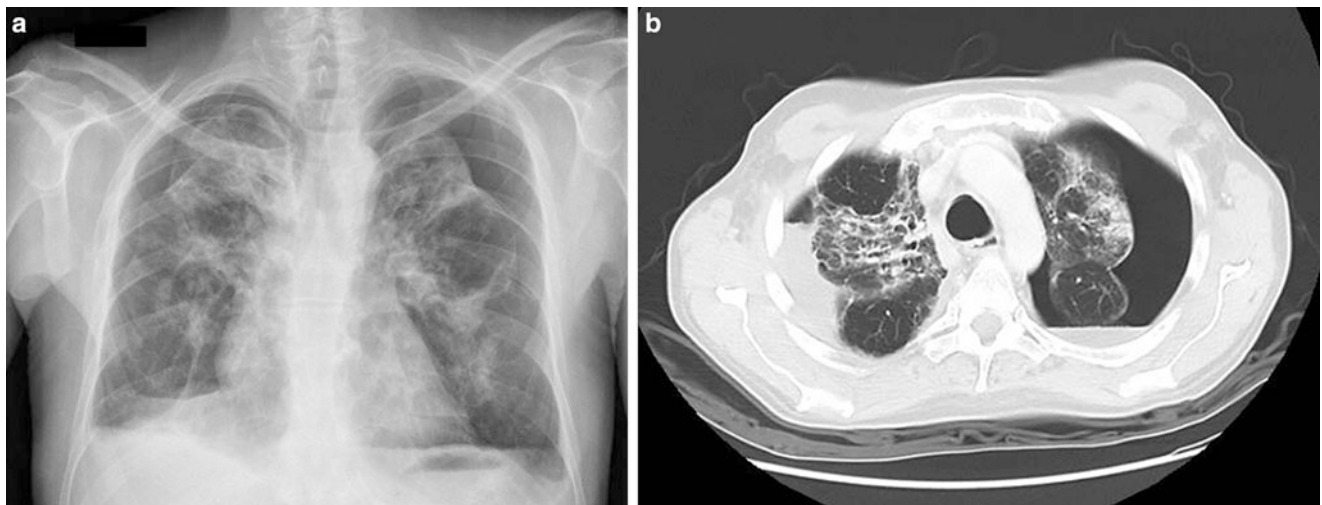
This 37-year-old patient received an allogeneic HSCT from his HLA-identical sister for refractory Hodgkin disease 20 months ago. He developed chronic respiratory failure due to concomitant causes: Hodgkin pulmonary relapse documented at 18 months and pulmonary fibrosis likely favored by previous mediastinum irradiation. (a) The chest X-ray shows bilateral partial pneumothorax, more important on the left side, bilateral pleural effusions, and multiple condensations. (b) The CT scan confirms the multiple retractor lesions of the lungs with bronchial dilatations and pleural thickening. It also confirms the left pneumothorax.
